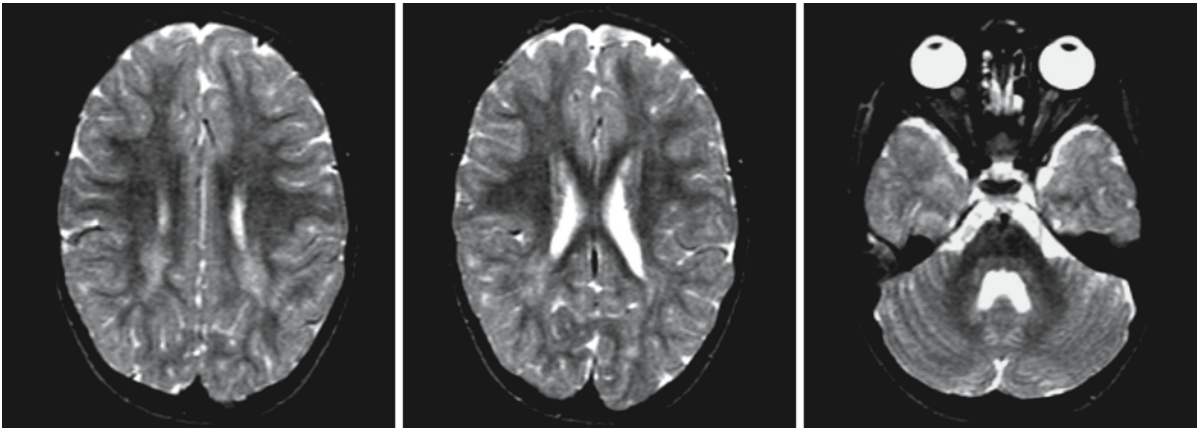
Girl with cobalamin deficiency, 19 months old at the time of the first MRI (*first and second row*). She was breast-fed and her mother, being vegan, had a cobalamin deficiency. These T₂-weighted MR images suggest a combination of delayed and disturbed myelination of the cerebral hemispheres, and demyelination and gliosis in the tracts under the pericentral cortex. Corpus callosum, internal capsule, and brain stem are spared. In addition there is prominent cerebral atrophy
